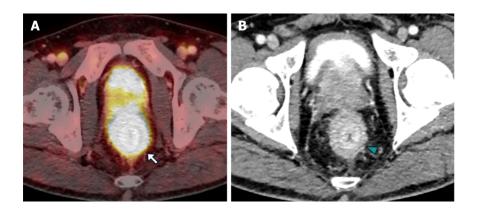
The positron emission tomography/computed tomography PSMA images in case 2. A and B: Axial FUSION (A) and computed tomography (B) of abdomen and pelvis with intravenous contrast revealed a stratified parietal thickening of the rectal wall, displaying significant uptake of the radiotracer, thus confirming the prostatic origin of the neoplastic infiltration (white arrow). Furthermore, concentric impregnation with intravenous contrast (green arrowhead) was also observed.
